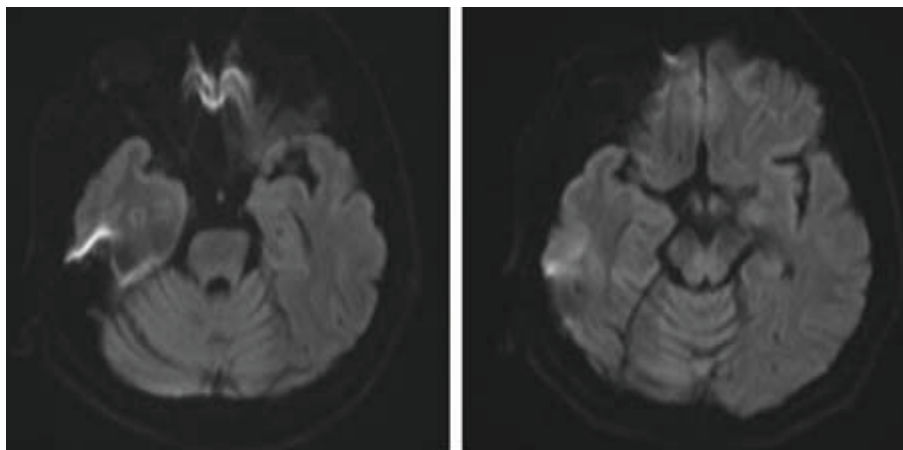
Initial DWI showing normal findings.
